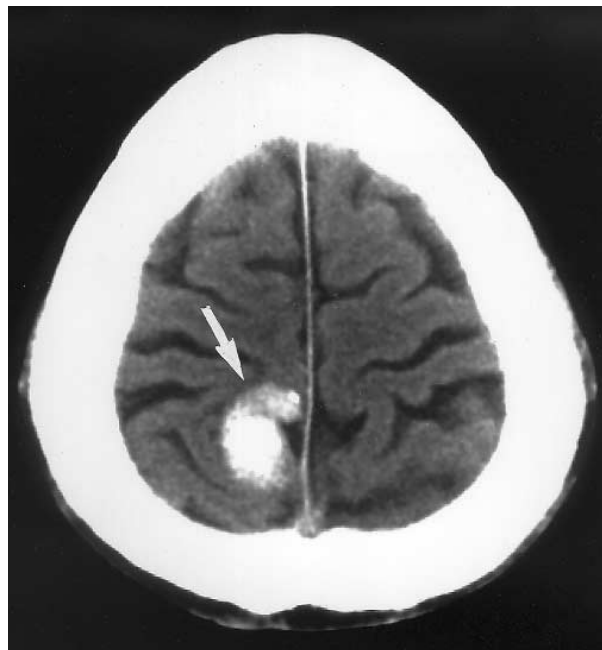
Unenhanced CT on the level of the high frontoparietal region. A hyperintense area, located in the right, parafalcine central gyrus (white arrow) is demonstrated, consistent with thrombosis of the former AVM.
